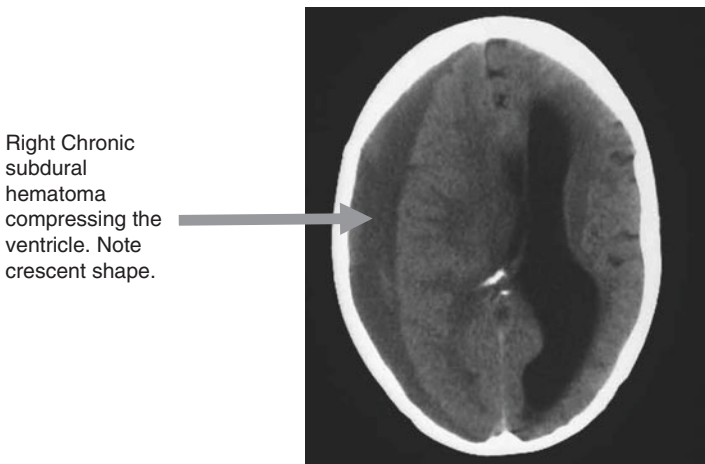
CT scan showing right *chronic* SDH; demonstrating again that subdural hematomas can spread from frontal area to occipital area without restriction so they tend to be shaped like a sickle or crescent with the concave surface towards the brain
